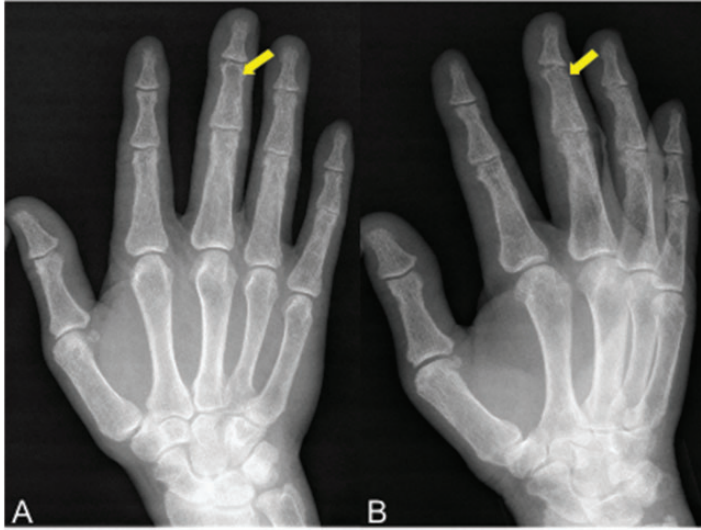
Standard anteroposterior (a) and oblique and (b) X-ray of the right hand.
